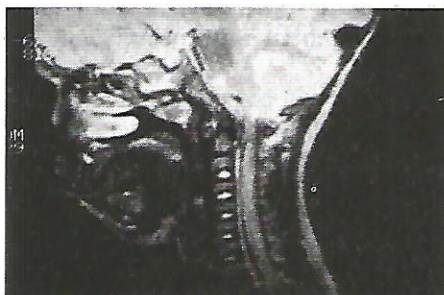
Sagittal MRI showing high signal in high cervical cord and PLL
